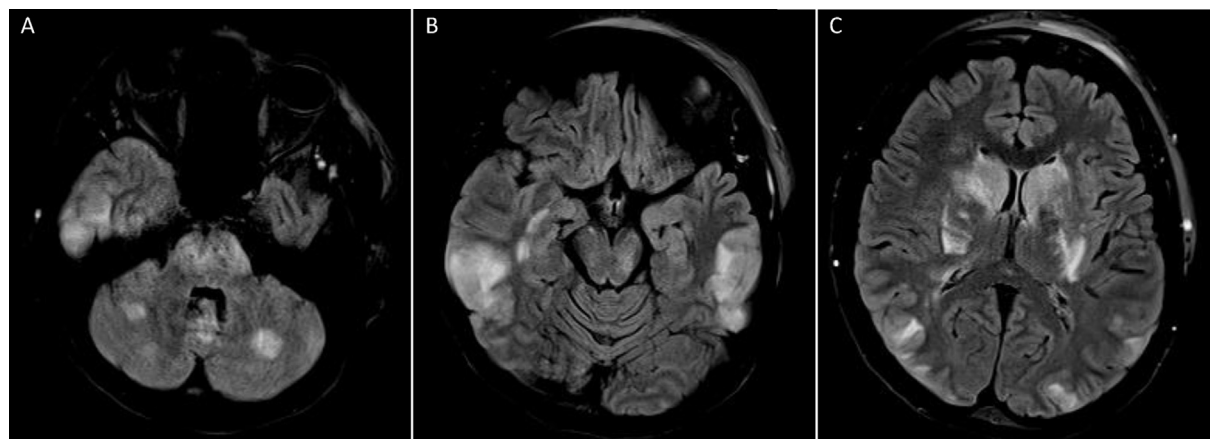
Magnetic resonance image of the brain shows increased T2/fluid-attenuated inversion recovery (FLAIR) signal in the (A) cerebellum, (B) bilateral posterior parietal, and (C) periventricular white matter, consistent with posterior reversible encephalopathy syndrome.
